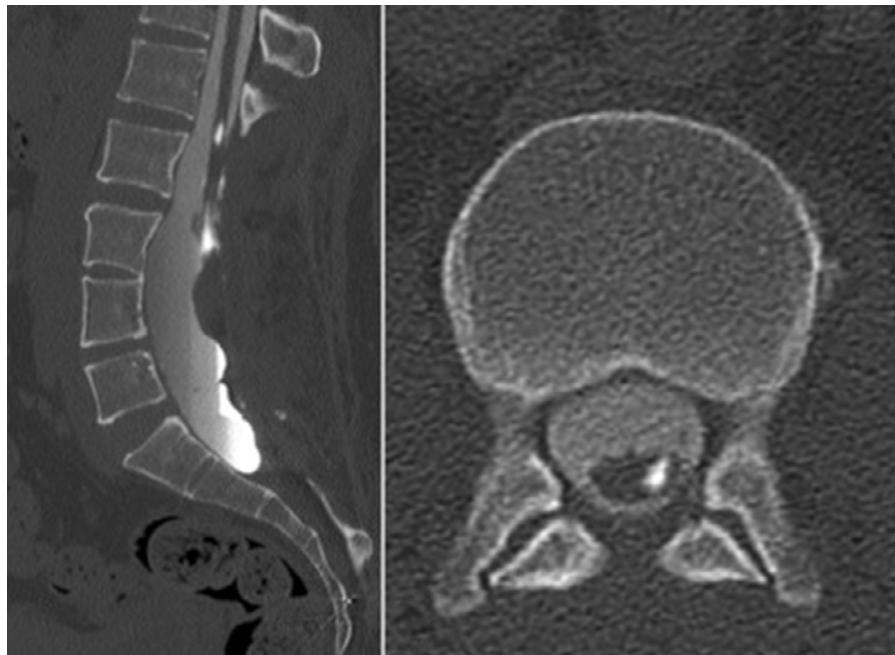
(Left) Sagittal CT image of the lumbar spine revealing a low-lying cord, partially tethered to the overlying soft tissues posterior to L3. (Right) Axial image at L1–L2 level showing a small focus of contrast within the left hemicord.
